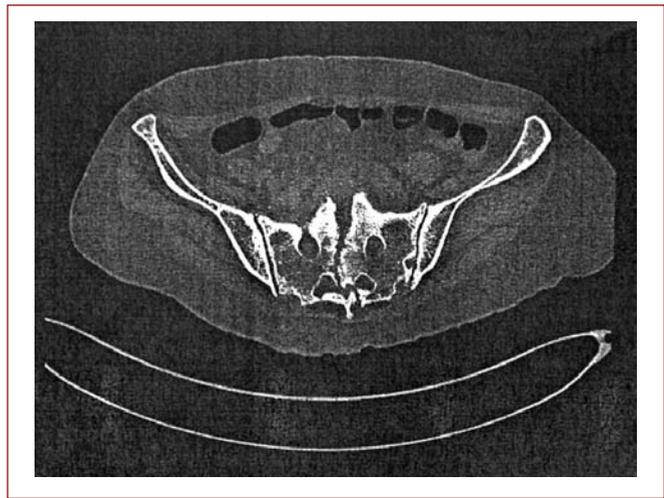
Preoperative CT showing central sacral fracture
